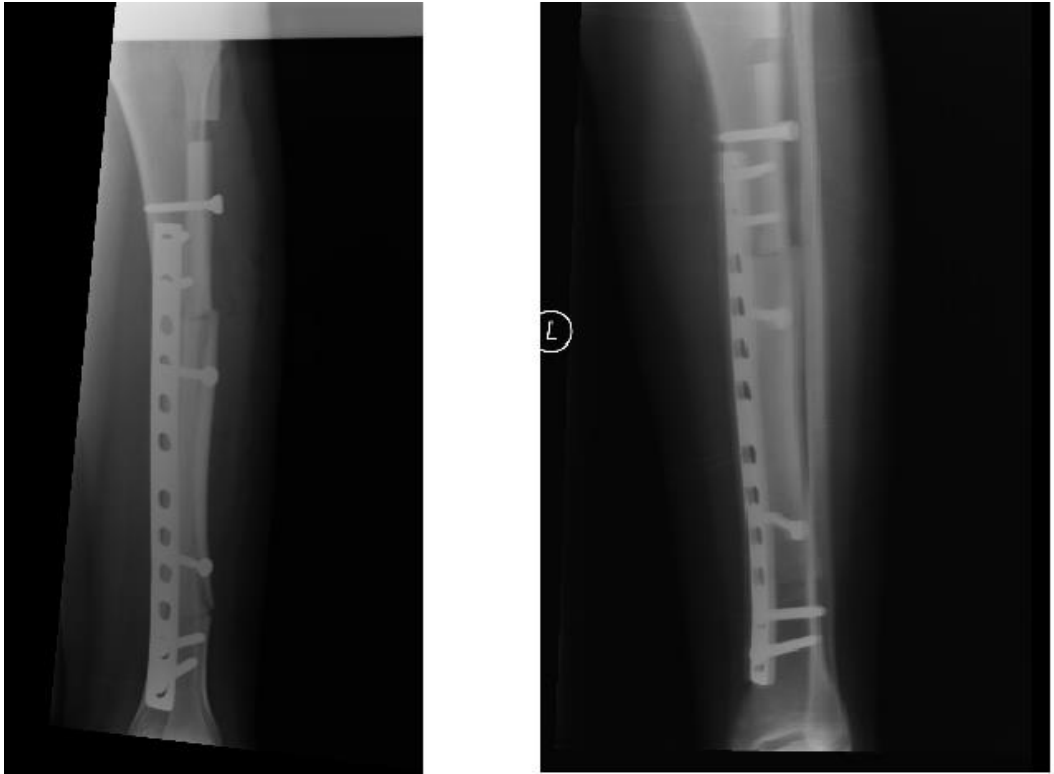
Early postoperative X-ray
